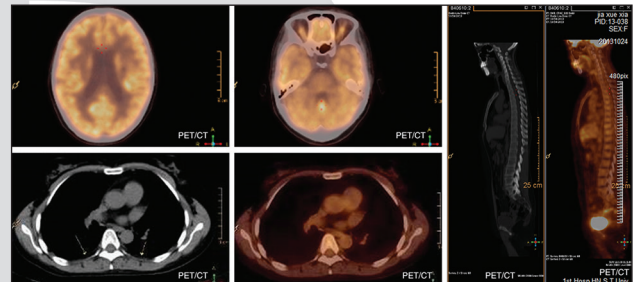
A positron emission tomography/computed tomography scan showed complete remission
